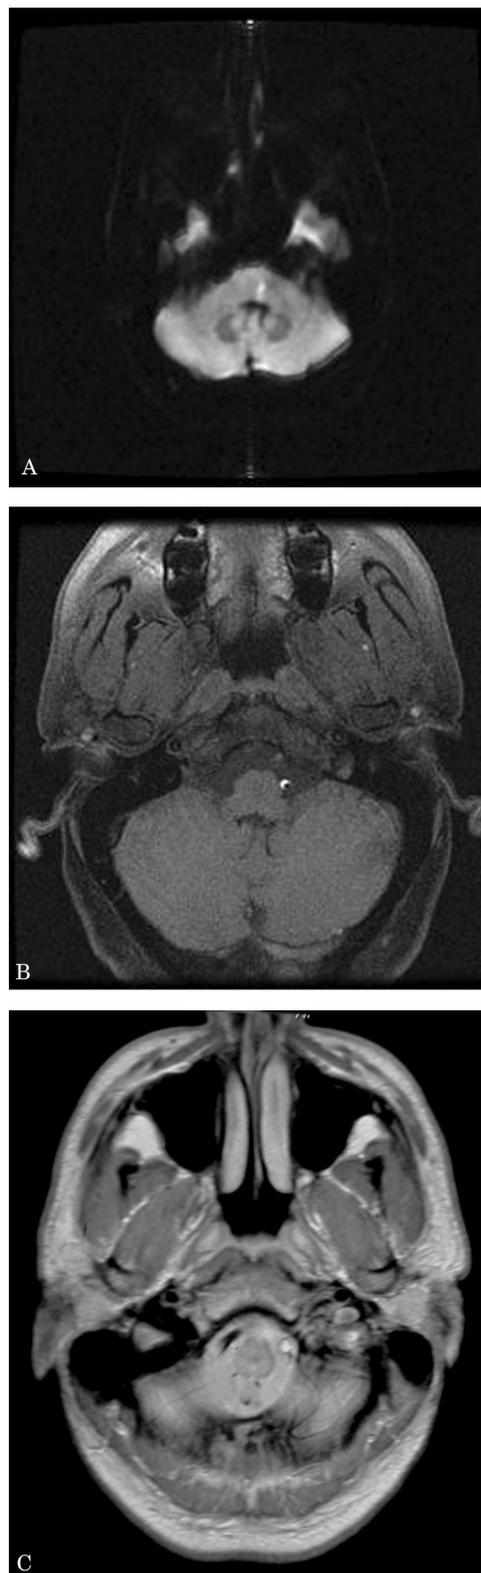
MRI appearances on admission. (A) Diffusion-weighted MRI with acute lateral medullary infarct. (B) Axial T1-weighted MRI with fat suppression demonstrating intramural hematoma within the left vertebral artery. (C) Earlier MRI demonstrating absence of the left vertebral artery flow void and intraluminal high signal.
